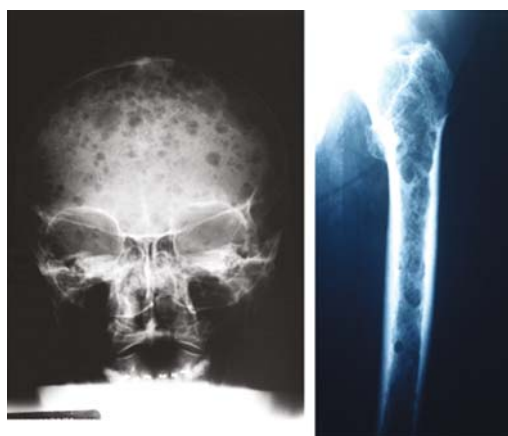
Plain film radiographs of lytic bone lesions in Multiple Myeloma. Courtesy of Dr. Mankin at the Massachusetts General Hospital.
